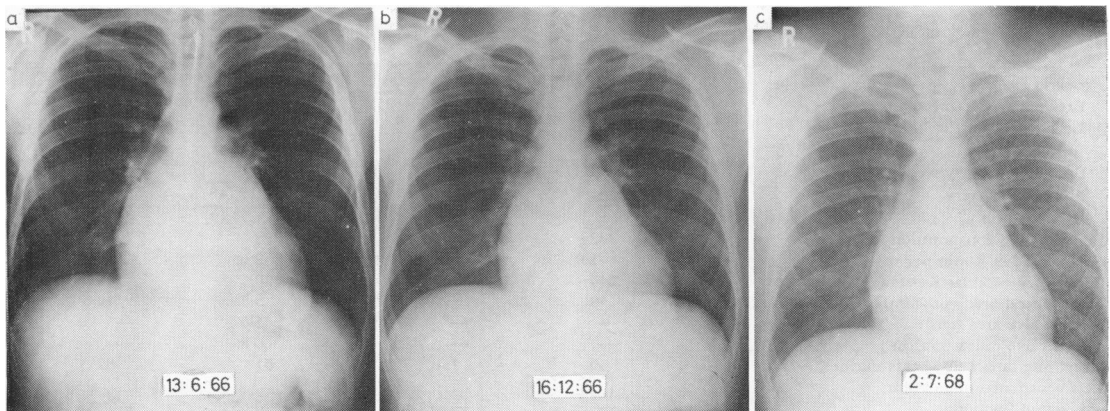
Preoperative chest x-ray film, June 1966 (a), showing cardiomegaly with enlargement of the left ventricle and left atrium; six months after operation there is some reduction in heart size; and two years later (c) there is enlargement of the left atrium.
